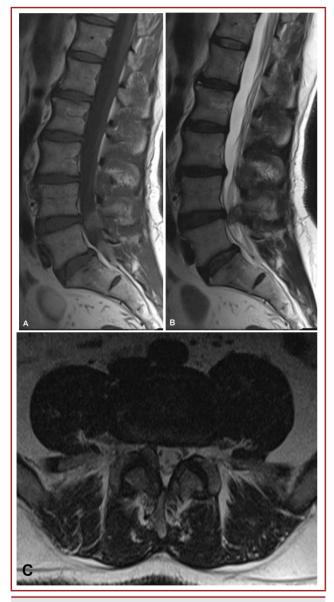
Posterior epidural mass lesion is seen that is hypointense on (a) sagittal T1-weighted MR image and heterogenous on (b) sagittal T2-weighted MR image. This mass lesion exerts significant compression to right L5 root (c) Axial T2-weighted MR image.
